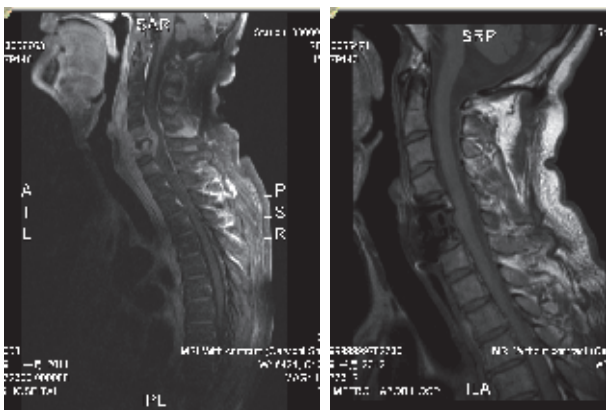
Magnetic resonance imaging of the lesion of the cervical spinal epidural abscess at the C4–7 levels before (left) and after surgery (right)
